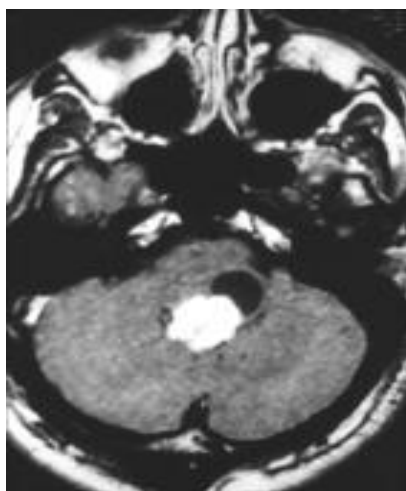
Left cerebellar hemangioblastoma. T2 sequence in contrast MRI.
